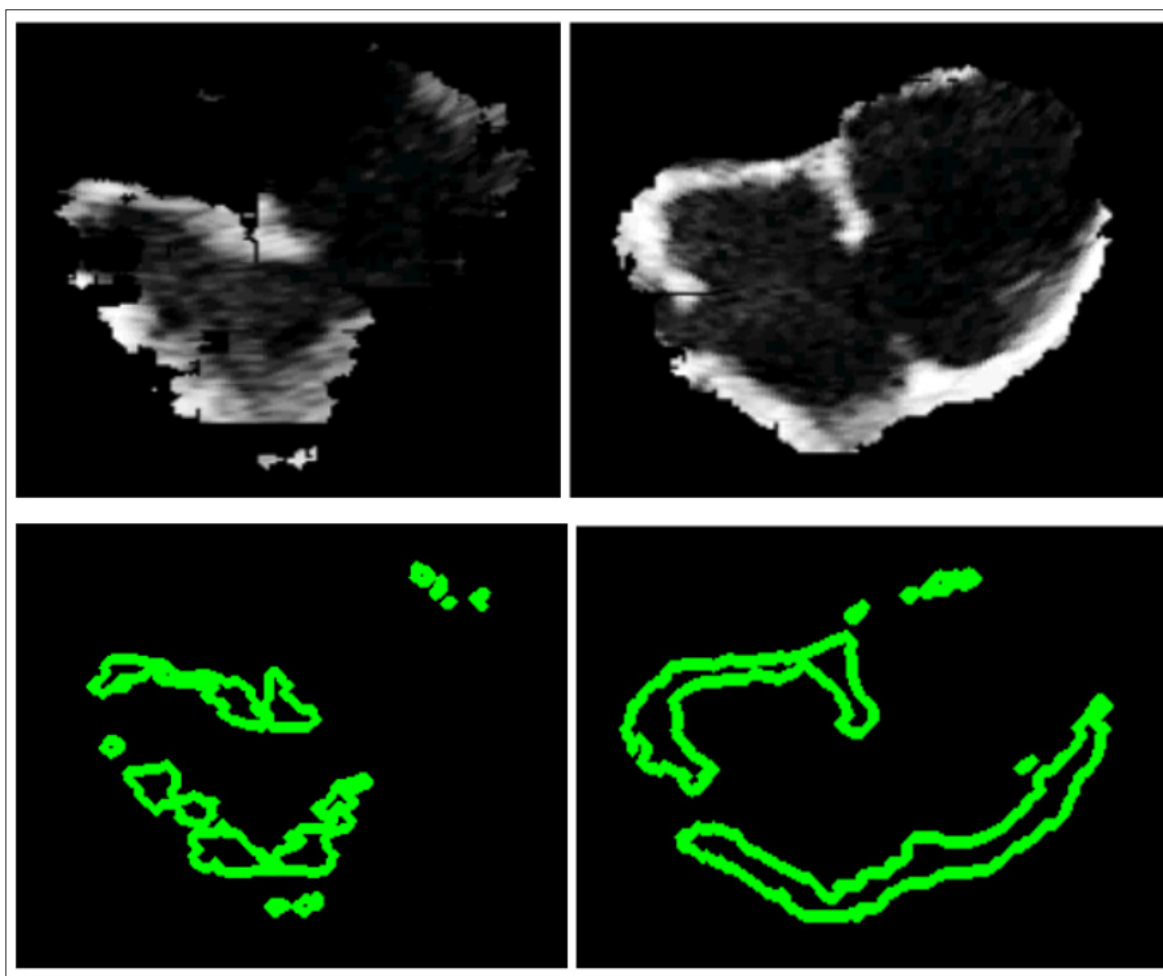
After obtaining the atrial contour, it is necessary to find and record the obtained result. Examples of contour extraction from echocardiography video frames: on the left is a “highly noisy” region of the atria, on the right is a noise-free region of the atria.
